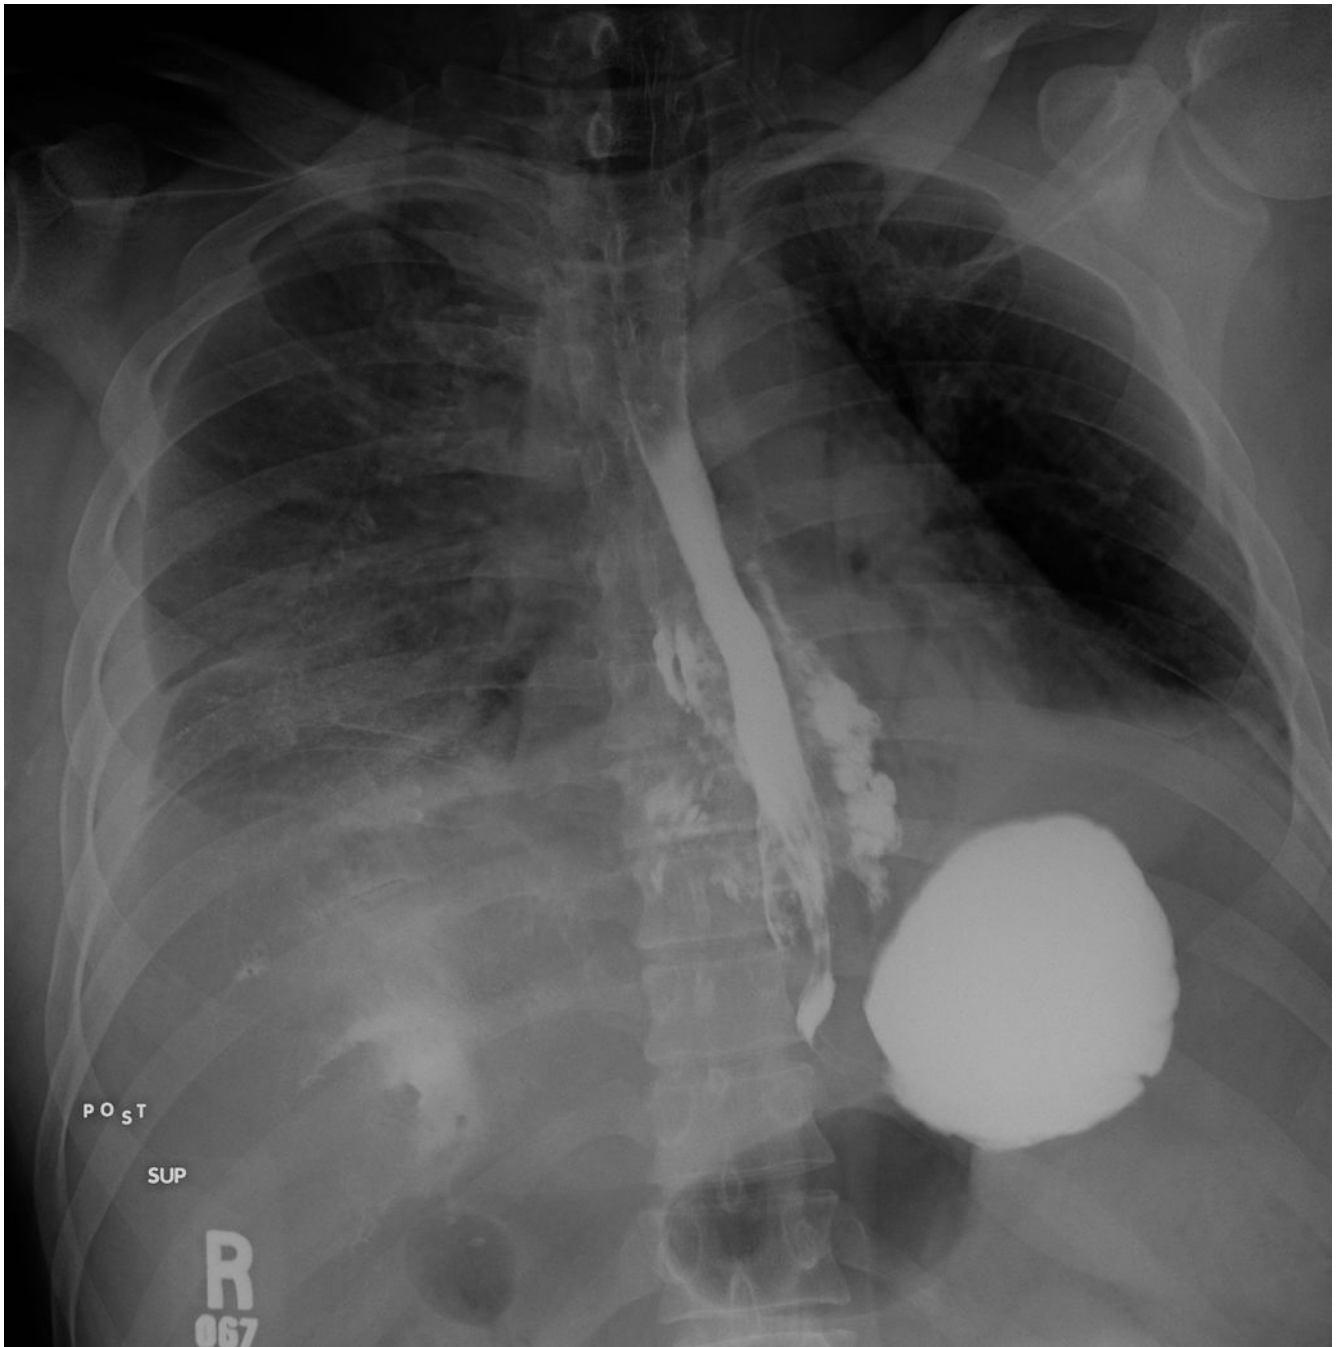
Examples of esophageal perforations in EoE patients. (A) Endoscopic view of a deep mucosal rent concerning for an esophageal perforation. (B) Noncontrasted chest CT scan in a different patient demonstrating diffuse esophageal wall thickening with associated paraesophageal stranding. A small amount of free mediastinal air can be seen (arrow), as well as paraesophageal fluid suggestive of phlegmon vs. abscess, suggesting a transmural
